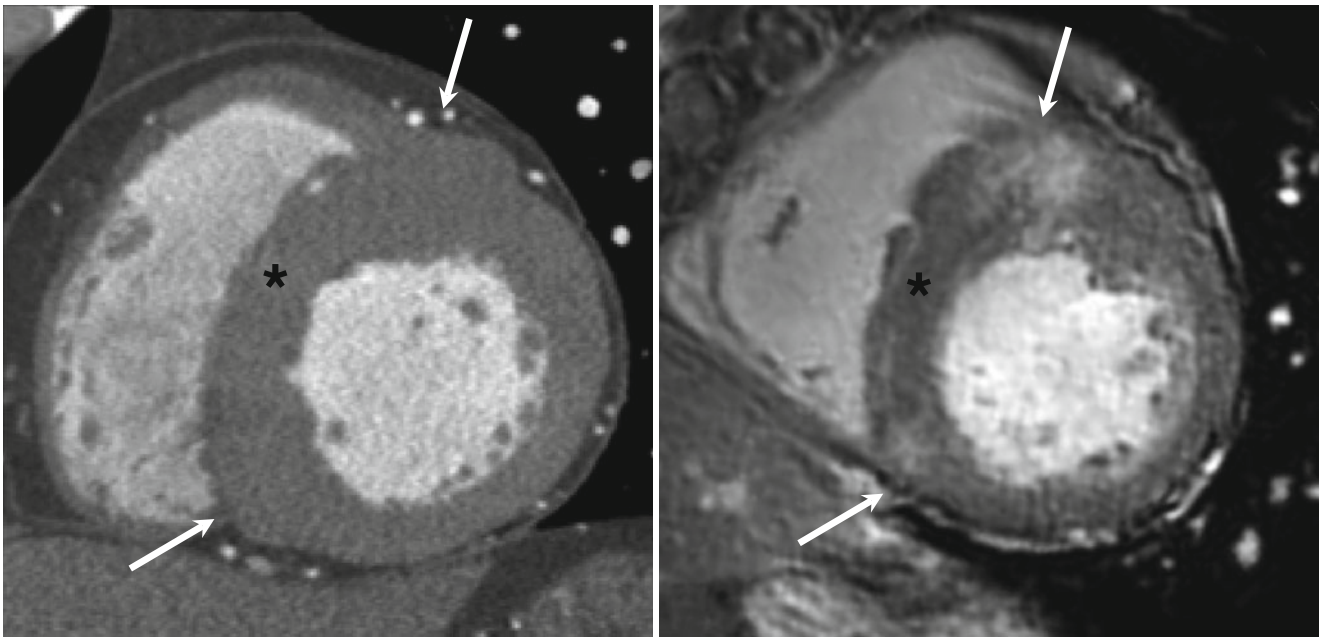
Noncontiguous HCM. (a) Short-axis MDCT image shows noncontiguous LV hypertrophy of the anteroseptal wall and inferoseptal wall (*arrows*) separated by septal areas of normal LV wall thickness (*asterisk*). (b) Short-axis delayed-enhanced MR image shows multifocal
